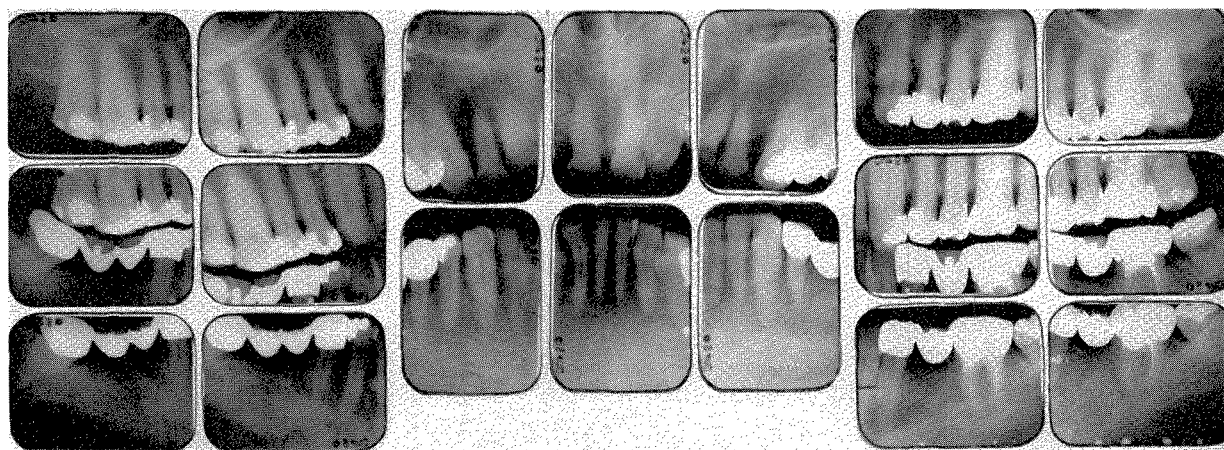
Roentgenograms of the patient taken in 1962, at the age of 72. The structures were in excellent condition.
